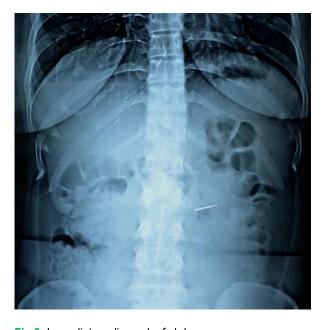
Immediate radiograph of abdomen.
